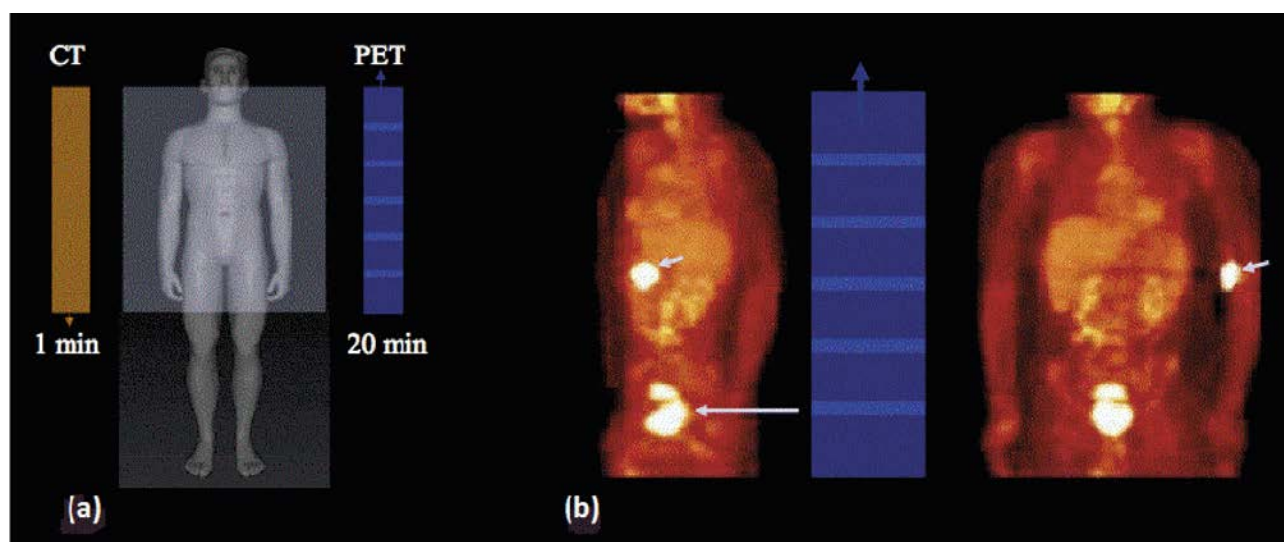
(a) Imaging sequence of whole body PET/CT; (b) maximum intensity projection images of AC-PET of a patient undergoing an FDG-PET/CT. The bladder was covered in two contiguous bed positions and the filling of the bladder increased during the lengthy imaging examination, leading to an asymmetrically expanded 'hypermetabolic' activity distribution in the vicinity of the bladder.
